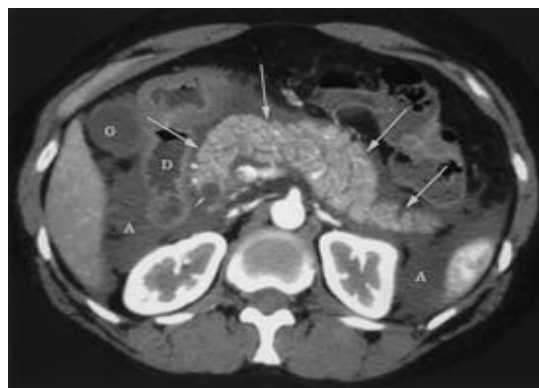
Contrast enhanced computed tomography scan of interstitial pancreatitis (n=43).
